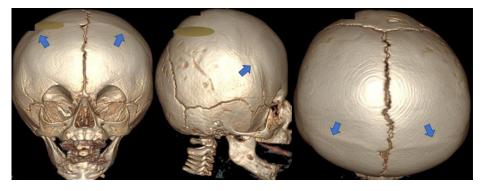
3D-CT reconstruction of skull with bicoronal synostosis (blue arrows) resulting in brachycephaly, frequently observed in classic CS syndromes.
